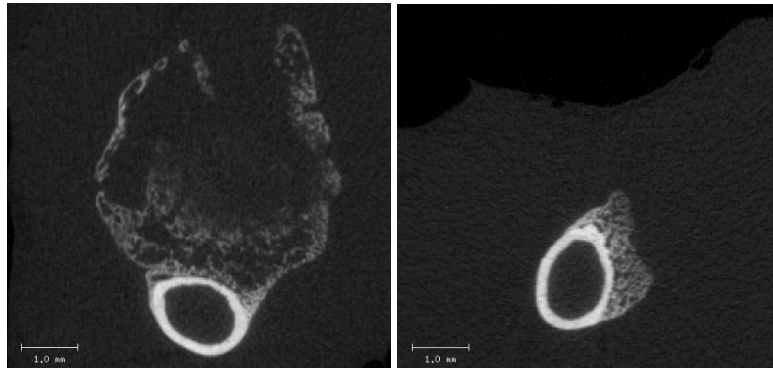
Position of Ectopic Bone Along the Femur. Above are cuts from the middle of the stack of μ CT images taken of the femur and ectopic bone. The right panel contains a cut from a sample from batch 1 of BMP-2, while the left panel contains a cut from a sample that received the BMP-2 from the second batch.
